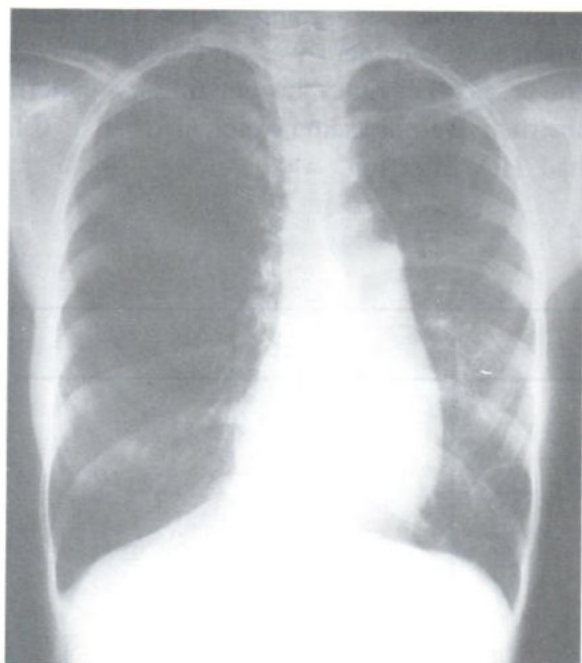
A 13 year old girl presented with weight loss. PA chest radiograph shows obstructive emphysema of the right lung with contra-lateral herniation of right lung. Minimal fibrosis in both upper lobes is noted.
